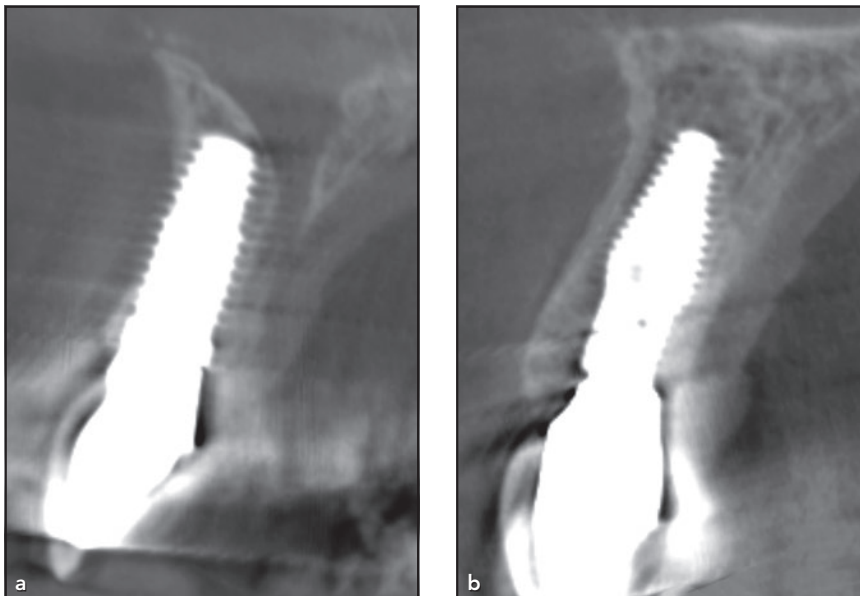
CBCT scans of (a) a tapered conventional implant and (b) an inverted body-shift (INV) implant placed into extraction sockets at 1 year of healing. The reformed labial plate dimension on the tapered implant is less than that of the INV implant.
